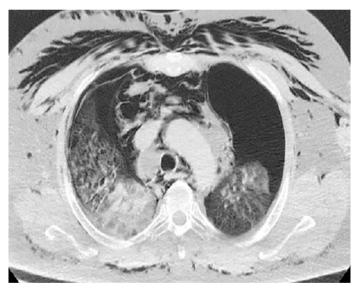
On thorax computed tomography, bilateral pneumothorax and pneumomediastinum findings are common subcutaneous emphysema, atelectatic lung parenchyma areas and accompanying peripheral sub-pelvral and peribronchial ground-glass infiltration areas.
